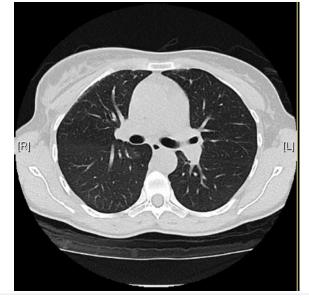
CT chest without contrast: "Right lower lobe opacities seen on prior exam have resolved and may have represented pneumonia or noninfectious inflammation."
